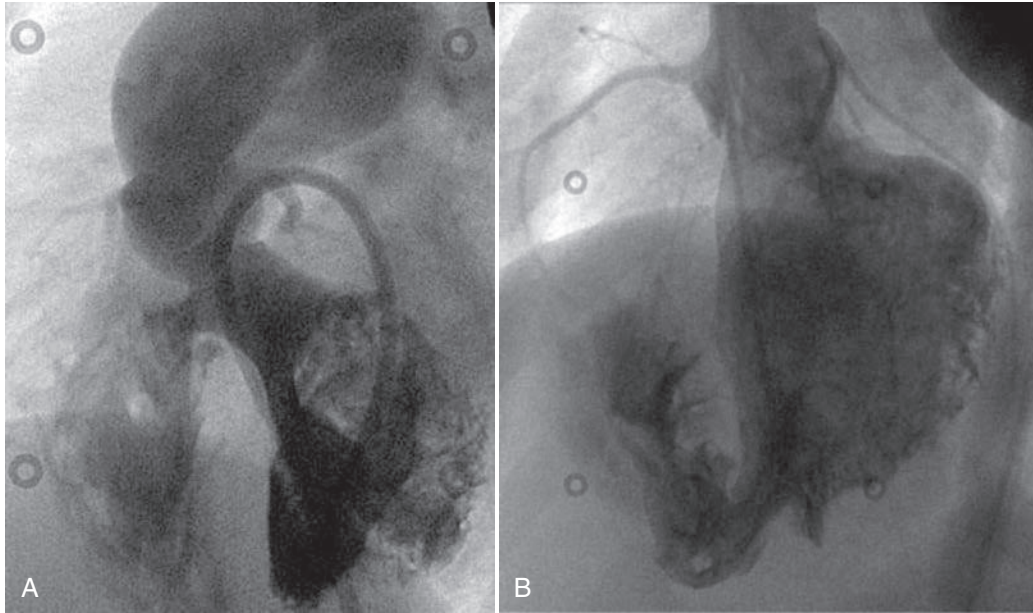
Left ventriculograms in the left anterior oblique projection demonstrating a perimembranous ventricular septal defect (VSD) (A) and a VSD located apically in the trabecular muscular septum (B). Apical trabecular muscular defects are often difficult to visualize by echocardiography.
